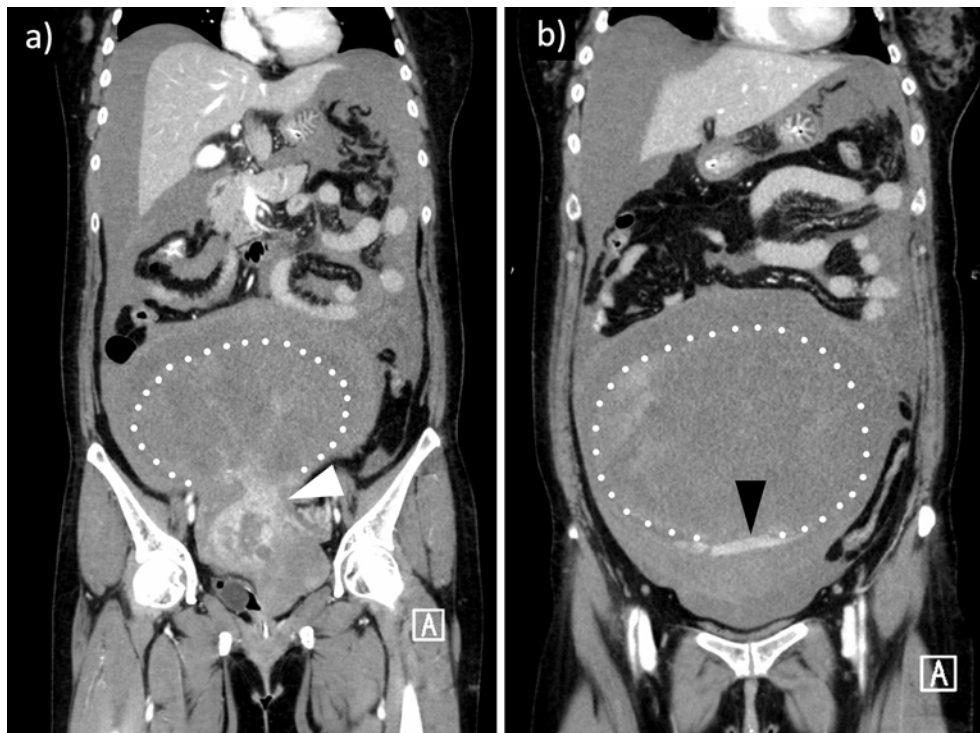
First abdominal contrast enhanced computed tomography images. a) Coronal view 1. b) Coronal view 2. These images show a giant uterine leiomyoma (white dotted lines), the stalk of the leiomyoma (white arrowhead), and a massive intra-abdominal hematoma. Extravasation (black arrowhead) is visible from the caudal aspect of the leiomyoma.
